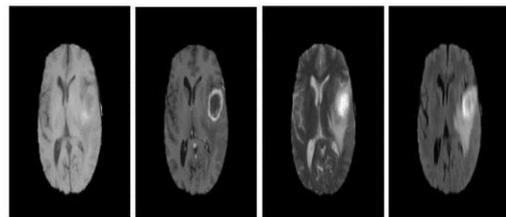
Four different standard models of MRI used for glioma diagnosis include T1, T2, T1-Gd and FLAIR.
